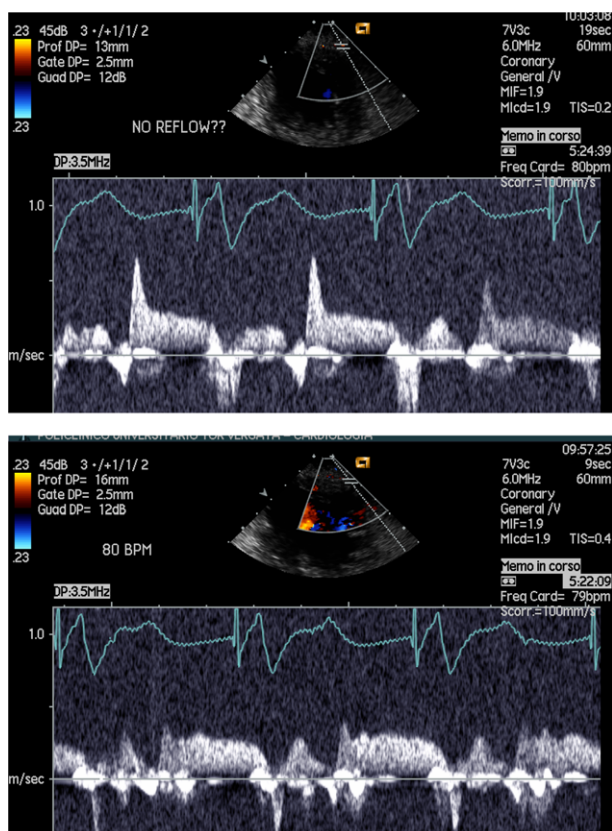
Transthoracic coronary Doppler ultrasound in a patient with normal coronary arteries, normal left ventricular function, and no history of acute myocardial infarction (AMI). Upper panel shows a pattern described as no-reflow (steep early diastolic deceleration slope and inverted systolic flow). Lower panel shows normalization of the diastolic pattern, after slightly tilting the probe, whereas it persists a retrograde early systolic signal. Therefore, these altered Doppler ultrasound signals can also be found in non AMI patients, are non-specific, and may be related to wall motion artefacts or venous flow.
